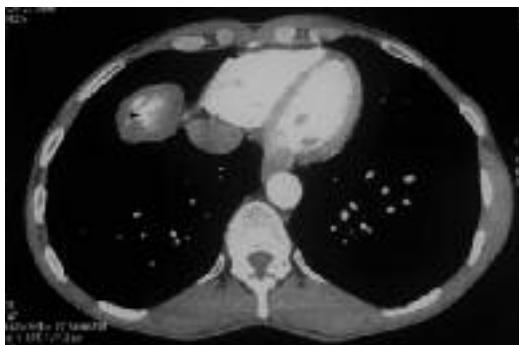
Axial Chest CT view with contrast material showing an intrathoracic extra parenchymal mass lesion neighboring the diaphragm with central coarse calcifications (arrowhead).
